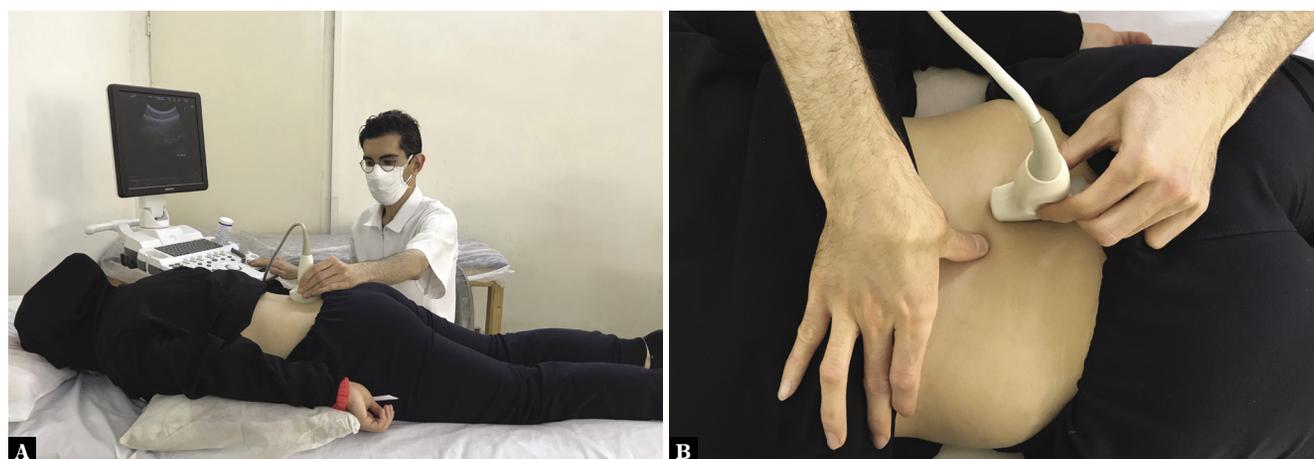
Sonography imaging of the lumbar multifidus muscles. A. Position of the patient. B. Position of the transducer
